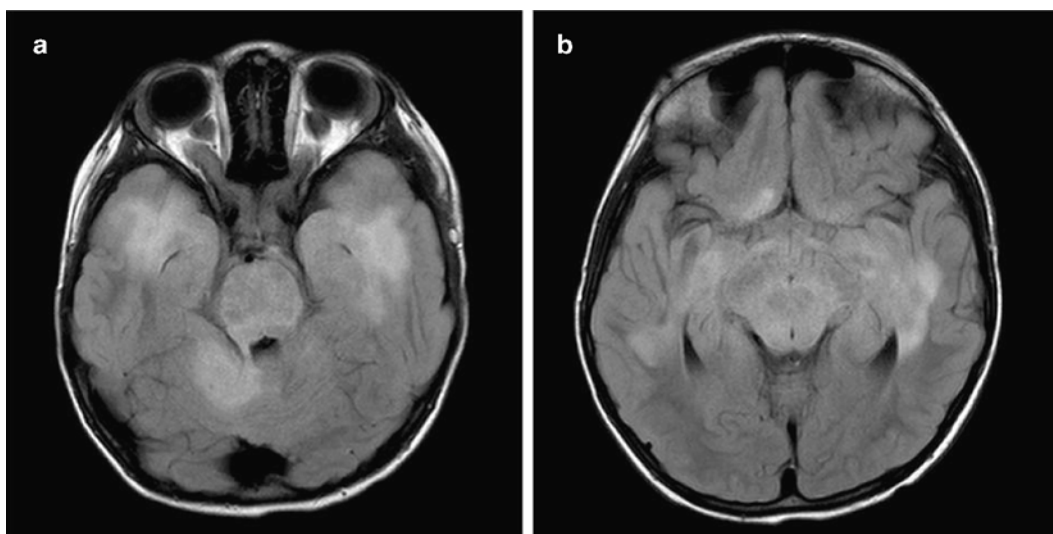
Pathognomonic MRI findings in NF1. Bilateral optic nerve glioma (a) and FASCI (b) are almost exclusively seen only in children with NF1.
